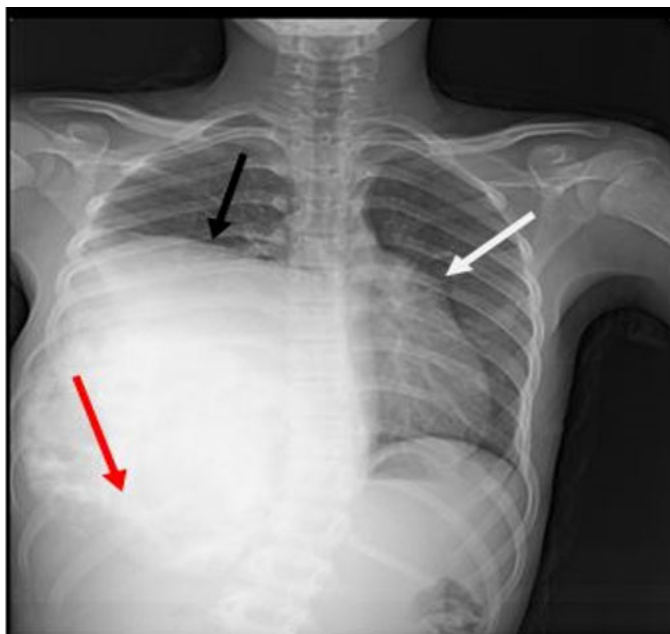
Frontal chest X-ray: Dense and homogeneous opacity, occupying the lower two-thirds of the right thoracic hemi-field, with a clear upper limit convex to the parenchyma (black arrow), pushing the mediastinum towards the contralateral side (white arrow), and erasing the homolateral diaphragmatic cupola (red arrow).
